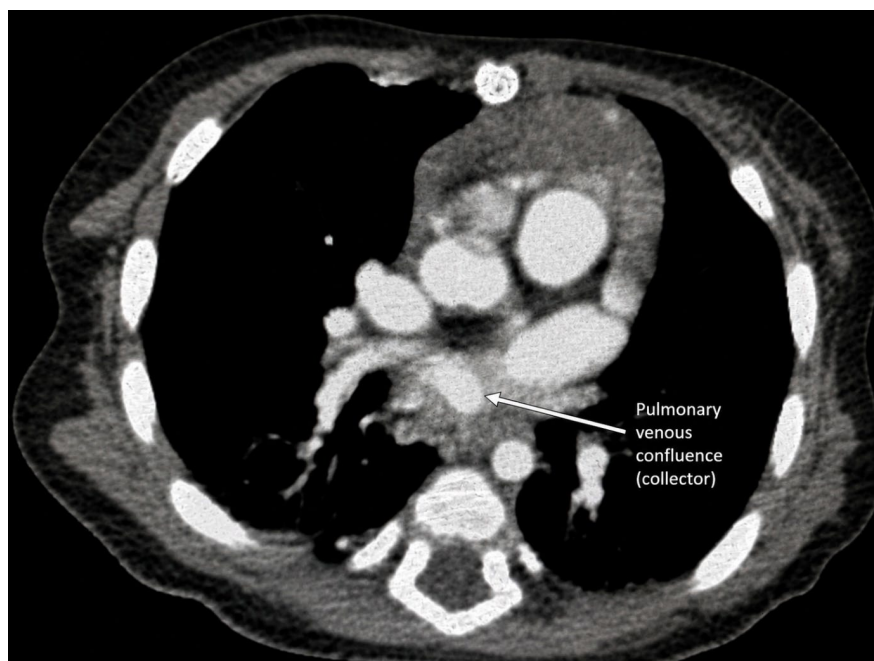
Thoracic CT angiography demonstrating the pulmonary venous confluence (collector).
